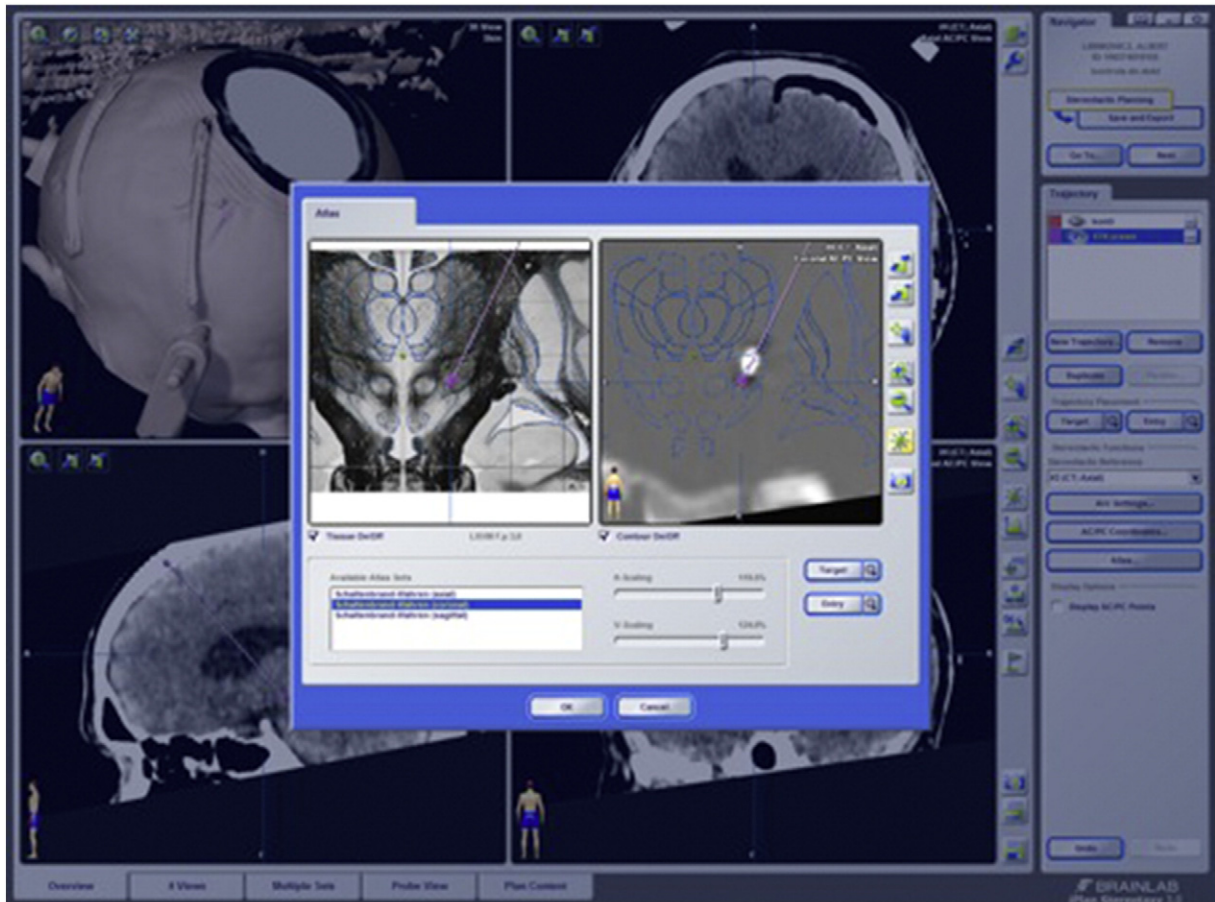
Unilateral STN DBS surgery. CT showing the first contact of electrode implanted to right STN fused with trajectory of intended target determined on brain anatomic atlas (coronal view).
